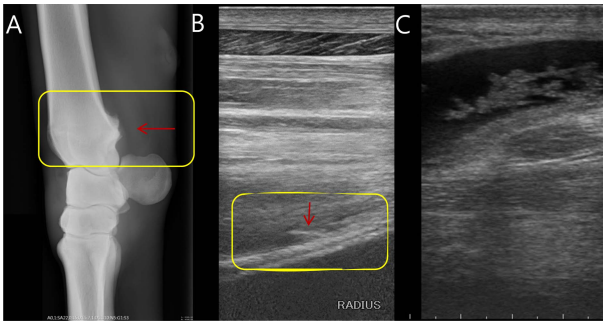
Radiographic and ultrasonographic findings. A bony protuberance was detected at the caudal and distal metaphysis of radius in a lateromedial radiographic image of the carpal joint (A, red arrow), and on longitudinal ultrasonography of the region indicated in A and B with yellow rectangles. Fibrin, secondary to tearing of the deep digital flexor tendon by the protruding osteochondroma, was detected in the proximal carpal sheath on ultrasonographic examination (C).
